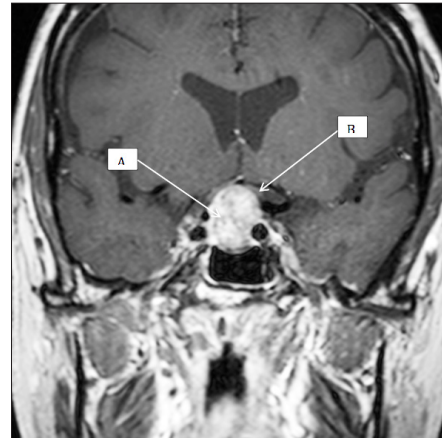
Coronal section of pituitary incidentaloma on MRI scan.
